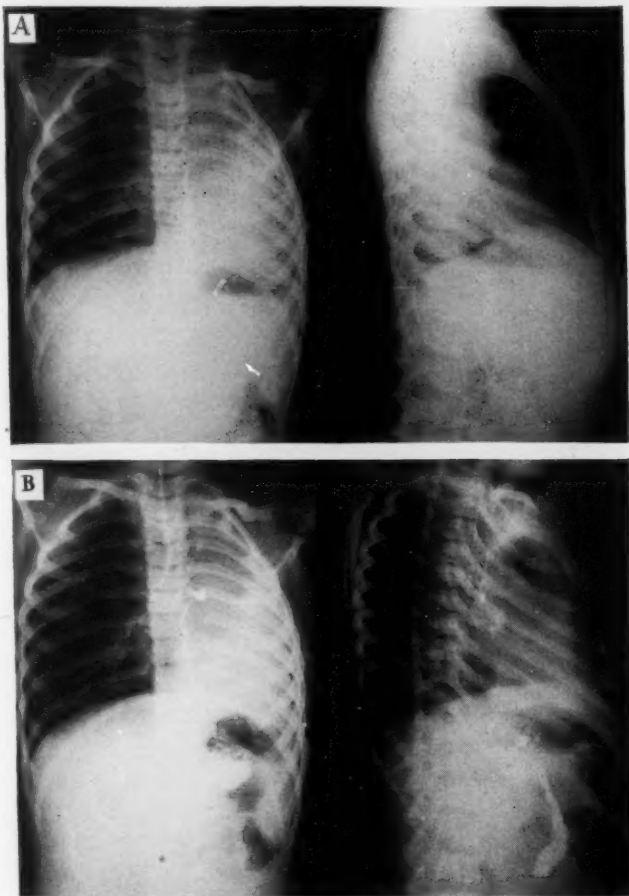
Case 3. Chest Roentgenograms showing collapse of the left lung. Herniation of the right lung to the left through the anterior mediastinum is noted on the lateral view.
